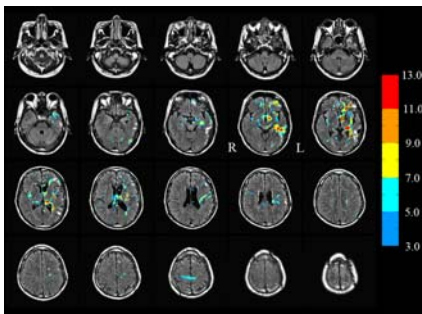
FA change (t -score in color bar) between TBI subject and 10 controls superposed on TBI subject's FLAIR images.
